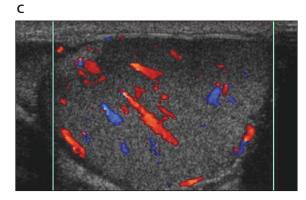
Intermittent testicular torsion. A, Transverse scan of a scrotum showing the short axis of the right testis (RT) and long axis of the left testis (LT) indicating the horizontally placed left testis. The left testis is slightly hypoechoic compared with the right testis. B, Color Doppler image of the right testis showing a normal flow pattern. C, Color Doppler image showing increased flow in the left testis.
